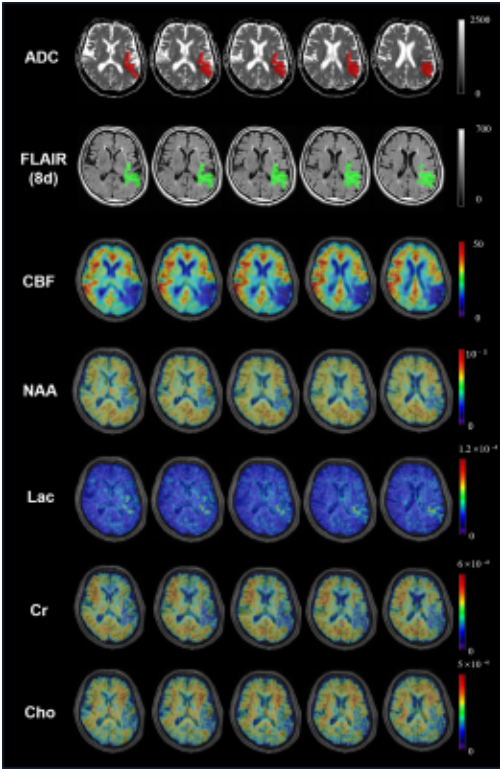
High-resolution metabolite maps of an acute stroke patient (<13h post onset) including NAA and Lac acquired in a 7-min scan. The corresponding acute ADC map, CBF map and the subacute FLAIR map are also included. The ADC lesion area was defined as ADC below $620 \times 10^{-6} \text{ mm}^2/\text{s}$. The perfusion deficit area was defined as CBF below 20 ml/100g/min. The infarct lesion mask was manually delineated on FLAIR image using image J software (1.46v, National Institutes of Health, USA).
